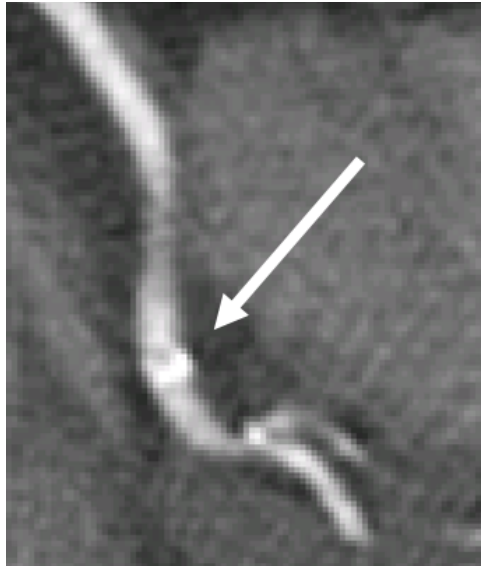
Appearance of a plaque in a CTA image: intensity and the shape of the bright spot suggest the presence of a calcification partially blocking the artery.
